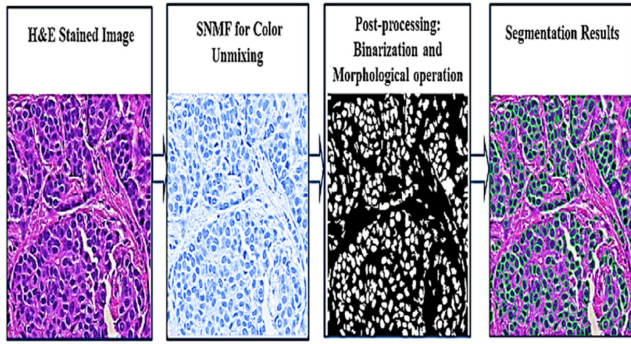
Sparse Non-Negative Matrix Factorization on tumor CT images.
